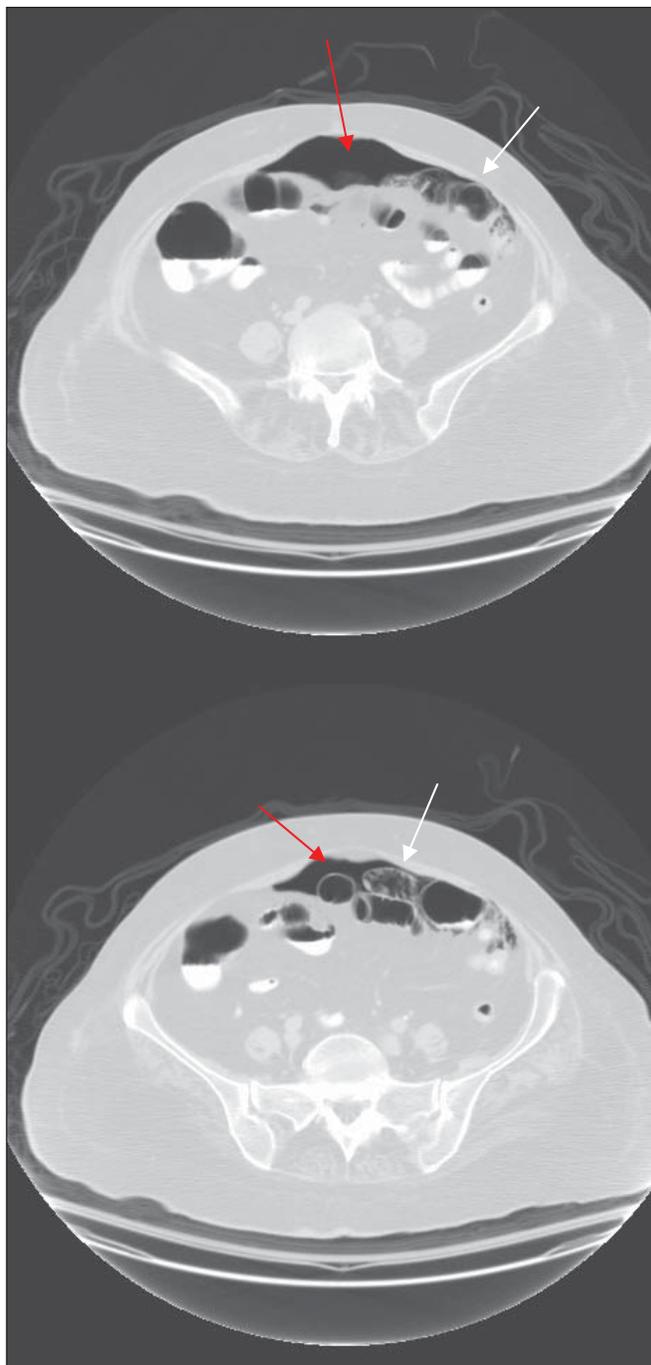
Computed tomography scan of the abdomen and pelvis of a 61-year-old woman with oral and intravenous contrast in lung windows demonstrating multiple small cystic spaces lining the bowel wall in the left lower quadrant (arrows) and free peritoneal air (red arrows).
